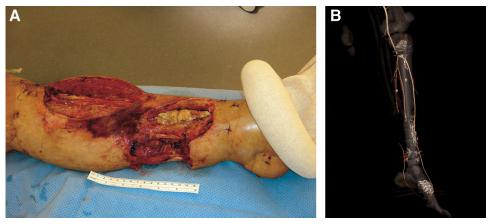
A, Presentation of the left lower extremity trauma at the time of initial consultation. B, Preoperative CT angiogram shows the transected posterior tibial artery. In addition, the peroneal artery is also transected. CT, computed tomography.
